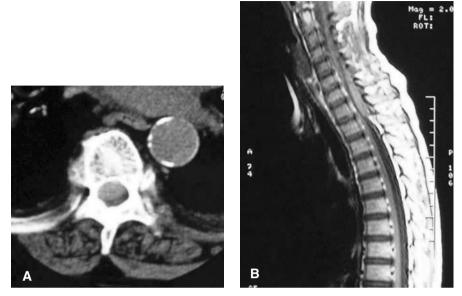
A Thoracic epidural hematoma: axial CT-scanner. B Cervico-thoracic epidural hematoma: sagittal T1-weighted MRI
